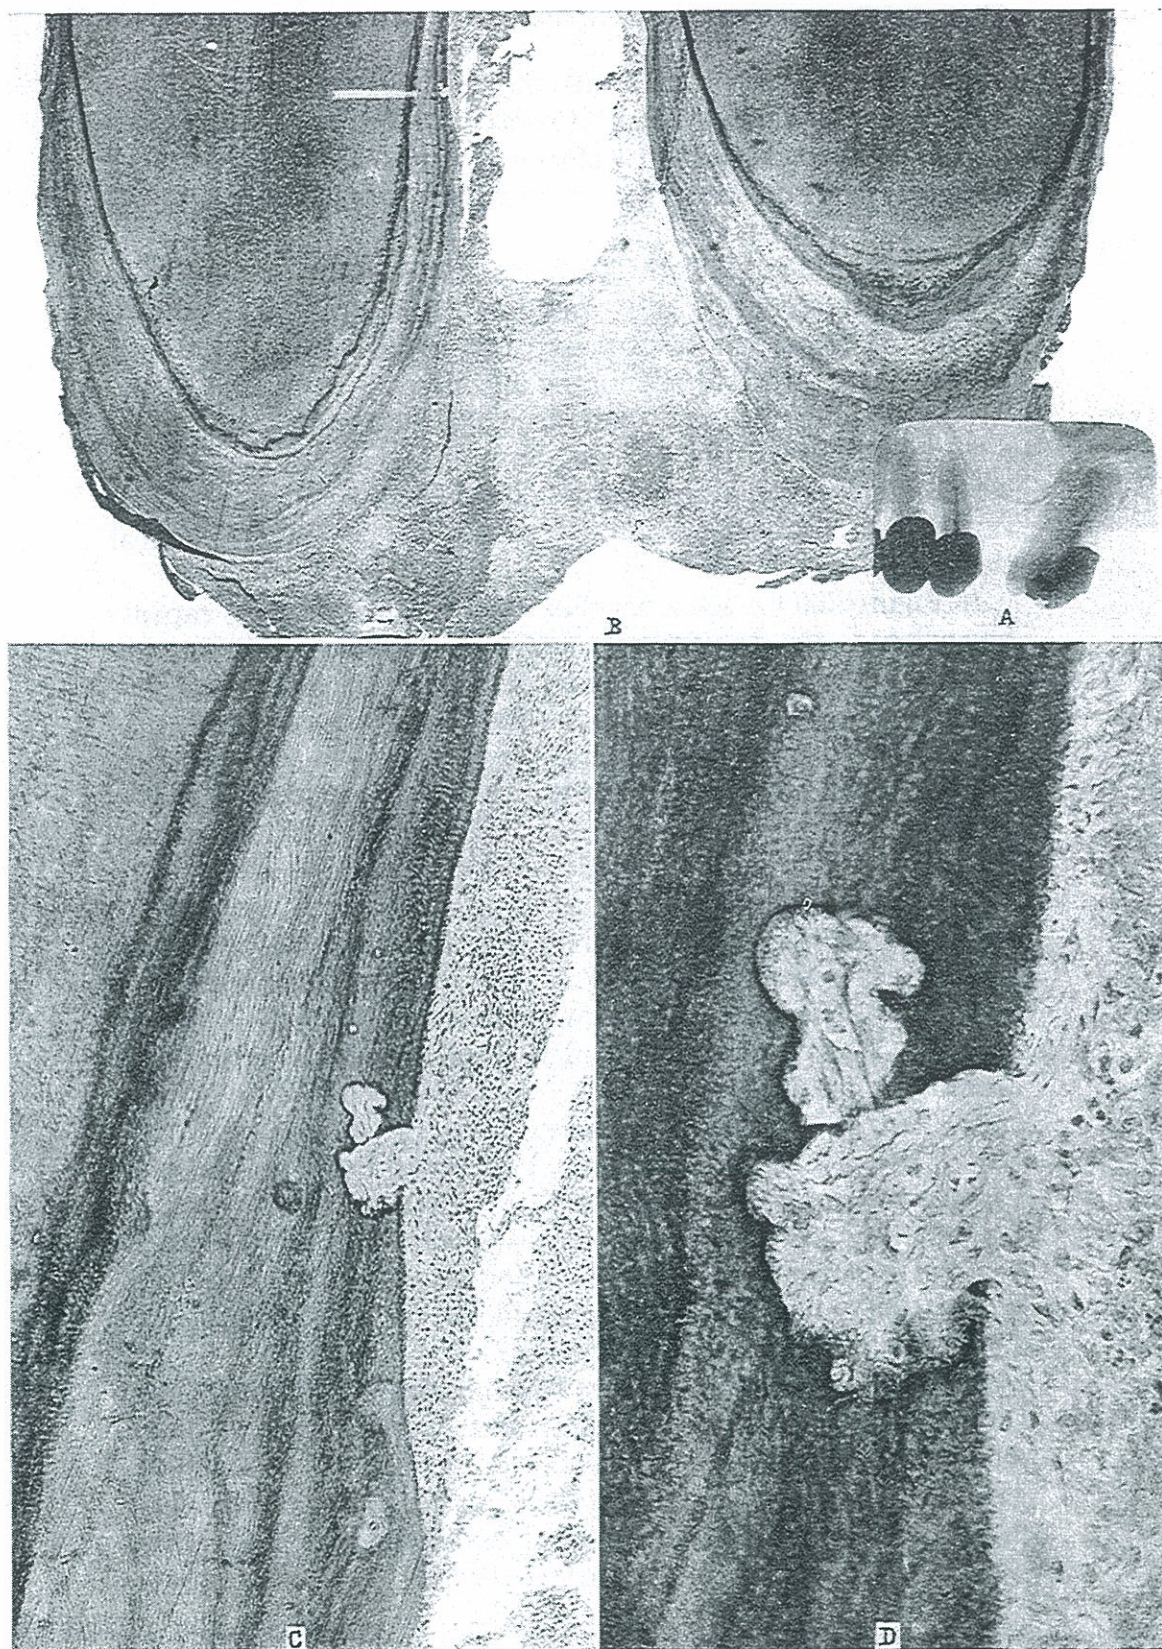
RESORPTION PROCESSES IN C AND D, FROM POINT OF ARROW IN B; A, ROENTGENOGRAPHIC APPEARANCE.
